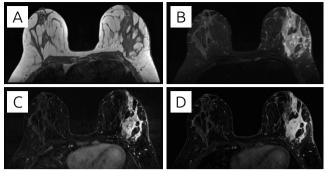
Magnetic resonance imaging enhancement.
